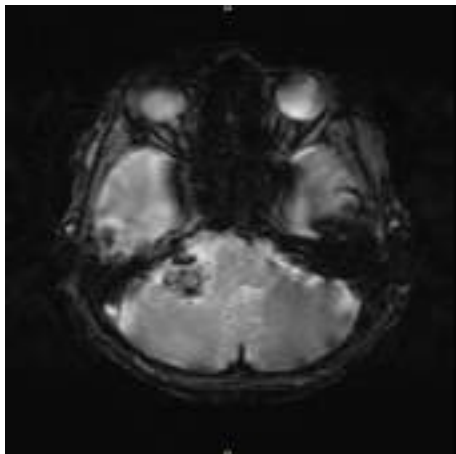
Postoperative MRI after neurosurgical intervention.
